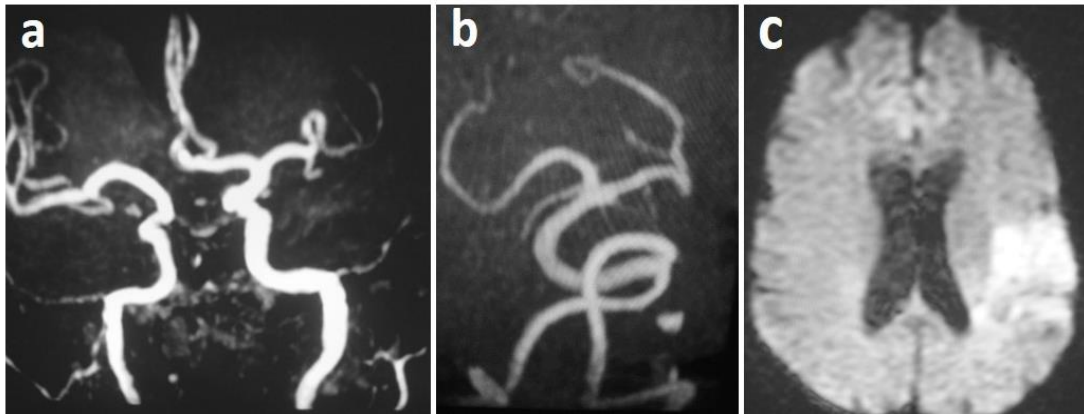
(a-c); (a&b) 3D TOF MRA show non visualized Lt. MCA M3 branches, associated absent A1 segment of Rt. ACA (normal variant) and Dolichoectasia of basilar artery (c) DWI b1000 shows a bright signal of acute infarction in the Lt. posterior parietal region.
